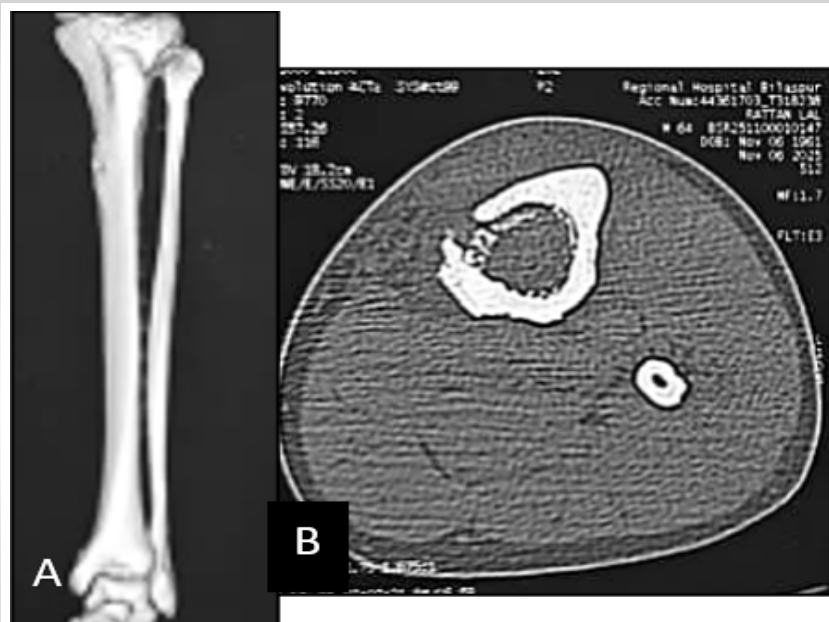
Preoperative computed tomography (CT) assessment of the left tibia. (a) Three-dimensional CT reconstruction demonstrating a well-defined defect in the proximal tibial metaphysis with cortical thinning. (b) Axial CT image revealing an intramedullary cavity with cortical erosion and adjacent periosteal reaction, consistent with a chronic osteomyelitic lesion.
